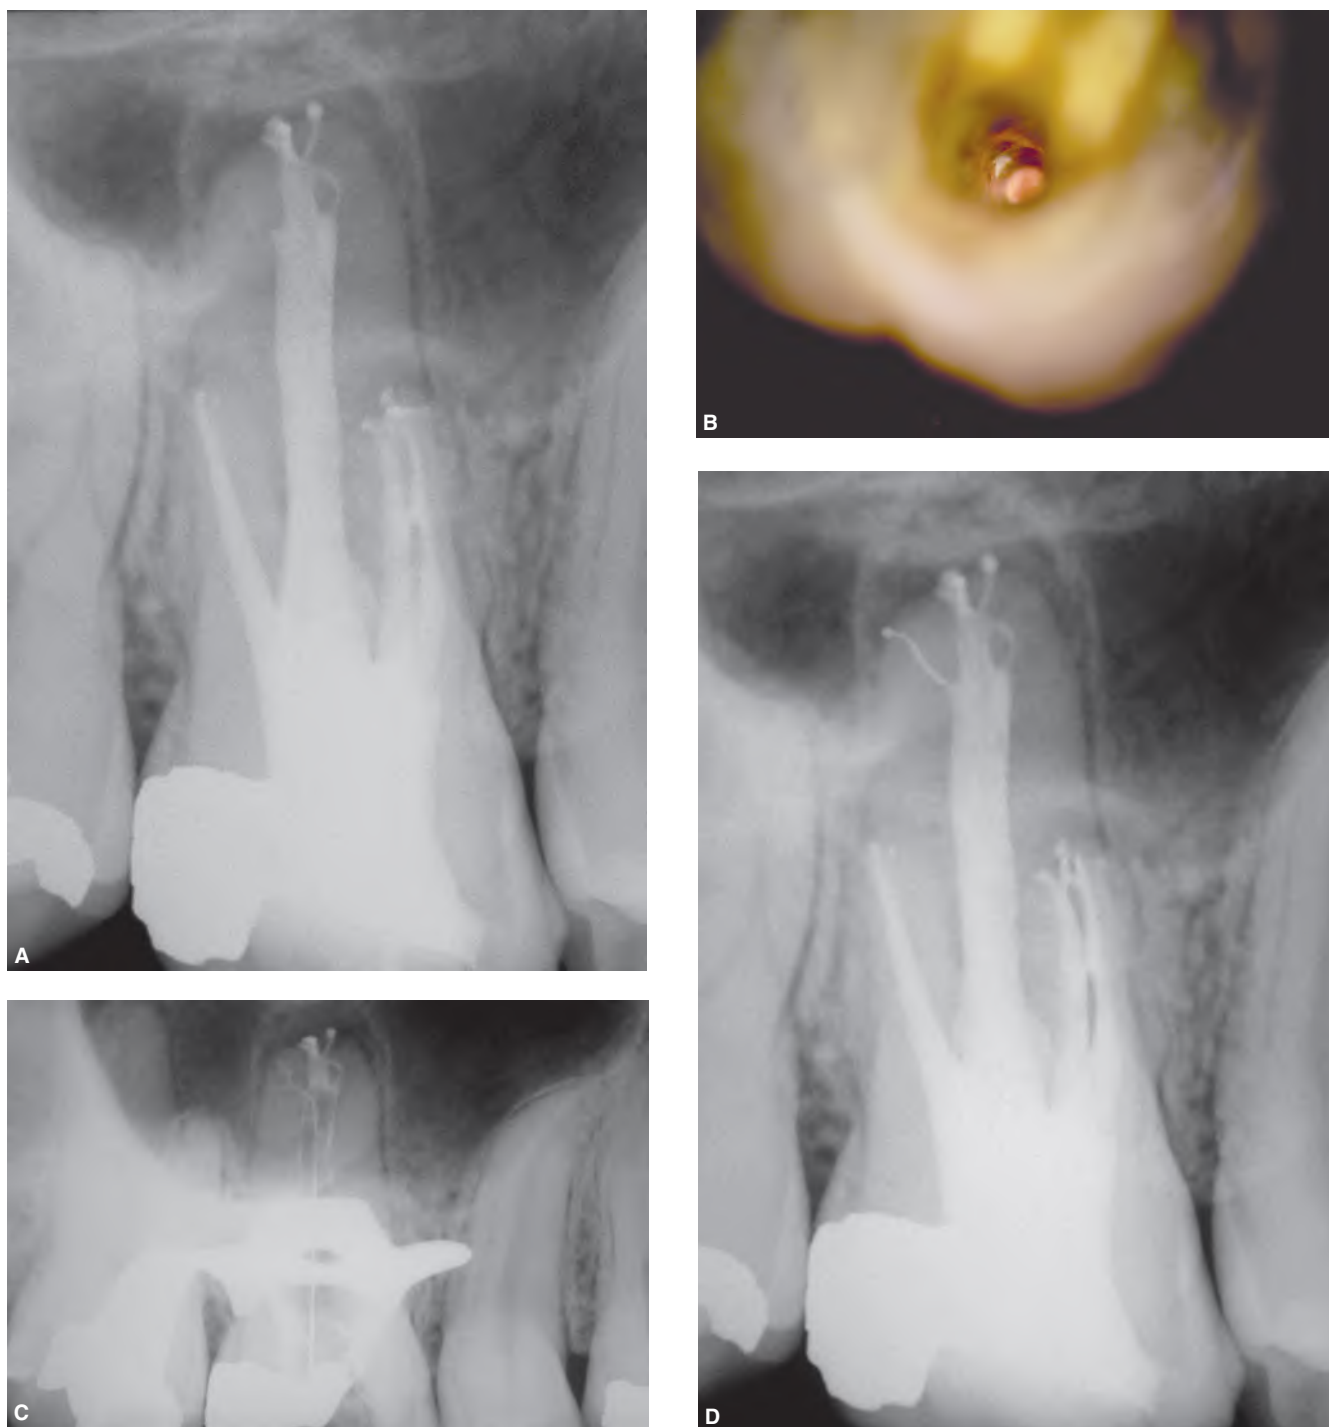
A. Radiograph of a maxillary right first molar with a failing treatment in the palatal root. B. A deep look into the apical one-third of the palatal canal reveals debris in the entrance to a lateral canal. C. Working radiograph demonstrates a no. 10 file moving through this ramification to its terminus. D. Post-treatment radiograph depicting the retreatment effort.
